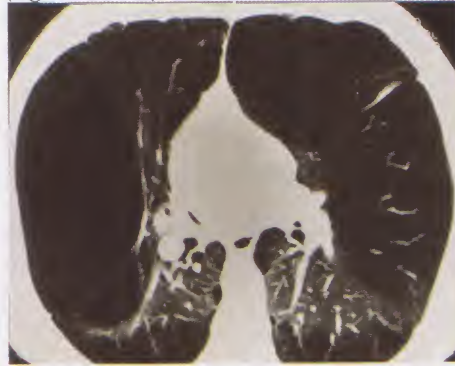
CT scan of emphysema with large air-filled bullae; note that only the narrow anterior junction line separates the two lungs at the front
